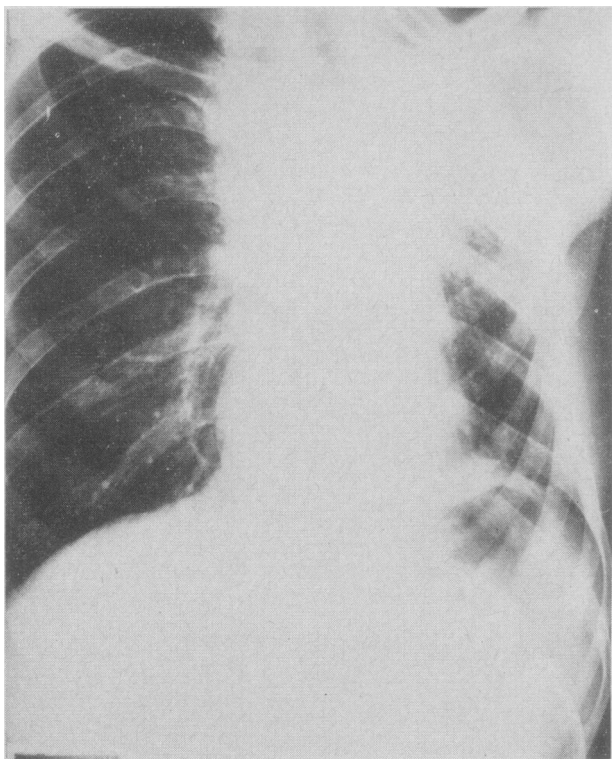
A later radiograph after the patient's clinical recovery, showing healed tuberculosis and radiation fibrosis in the left upper lobe.
